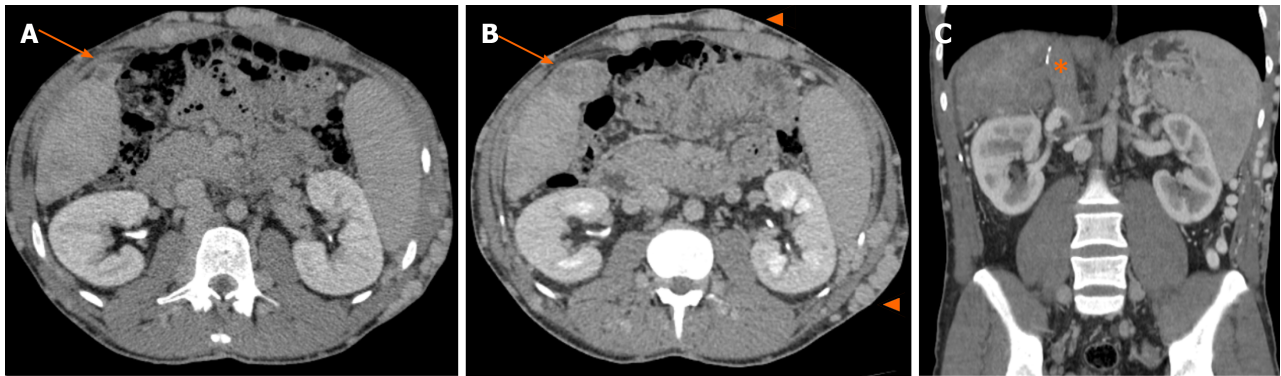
Abdominal computed tomography scans, with a 3-year interval. A: Heterogeneously vascularized nodule in segment V, of 2 cm, more visible in delayed phase due to hypocaptation (arrow); B: Same nodule in segment V in an exam scan performed 3 years later, with 4 cm (arrow). Massive subcutaneous veins in the abdominal wall are noted (arrowhead); C: The retrohepatic vena cava is completely thrombosed, up to almost the right atrium (asterisk).
